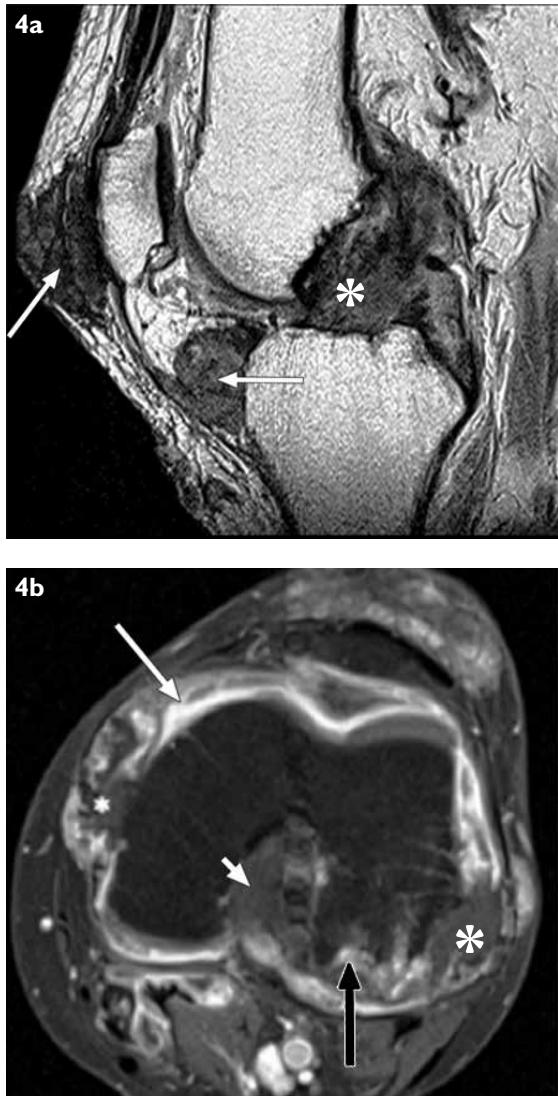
(a) Sagittal PD image of left knee shows a lobulated mass at the intercondylar notch, infiltrating the anterior cruciate ligament (asterisk). Similar masses of intermediate signal are seen in the Hoffa's fat pad and anterior to the patella (white arrows). (b) Post-contrast, fat-saturated axial TI-WI MR image of the left knee shows a non-enhancing tophus of intermediate signal surrounding the medial and lateral collateral ligaments (asterisk), as well as infiltrating the intercondylar notch (arrowhead). Note the erosion of the posterior lateral femoral condyle (black arrow) and thickened enhancing synovium (white arrow), reflecting synovitis.
